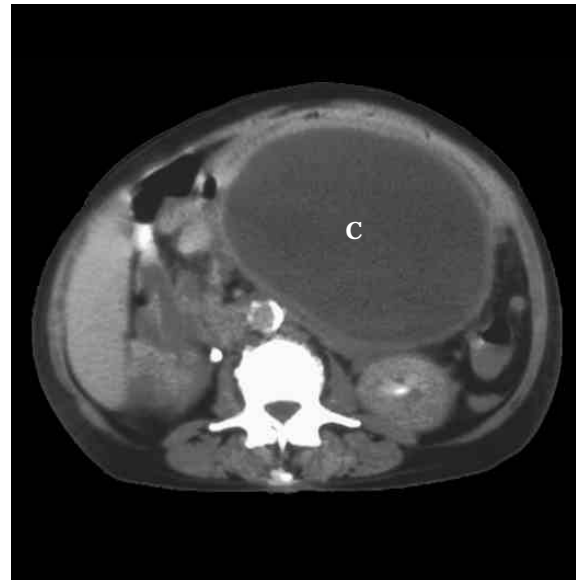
PANCREATIC CYST CT image. The cyst (C) contains pancreatic juices and dead tissue. Pancreatic cysts are commonly found in cases of chronic pancreatitis. Leakage and activation of pancreatic juices within the pancreas results in the digestion and destruction of the pancreas. Often found in chronic alcoholics.
